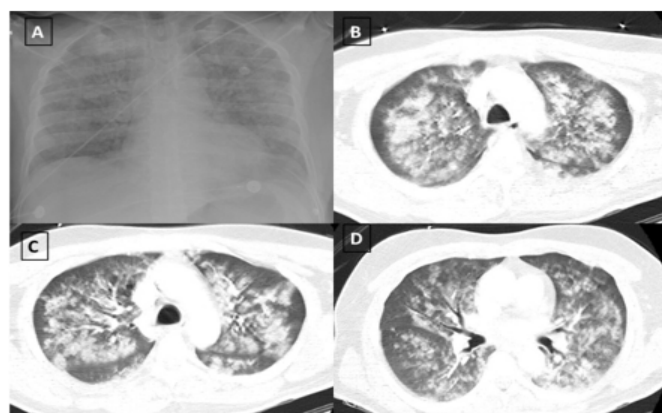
(A) Initial chest X-ray with opacity consistent with pulmonary edema, (B-D) bilateral alveolar filling defect and areas of consolidation consistent with pulmonary edema with preservation of the subpleural area.
